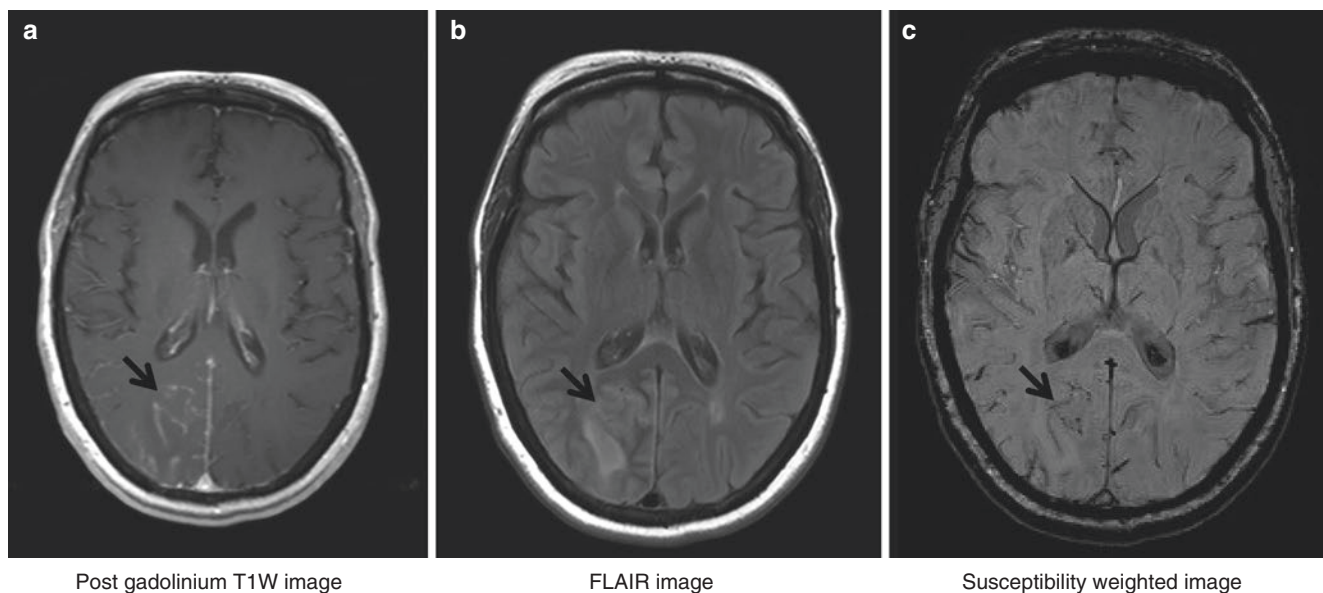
Magnetic resonance imaging (MRI) of the brain with gadolinium contrast of a patient of amyloid β (beta)-related angiitis. (a) Nodular leptomeningeal and parenchymal enhancement in right parieto-occipital region (black arrow) on post gadolinium T1-weighted
